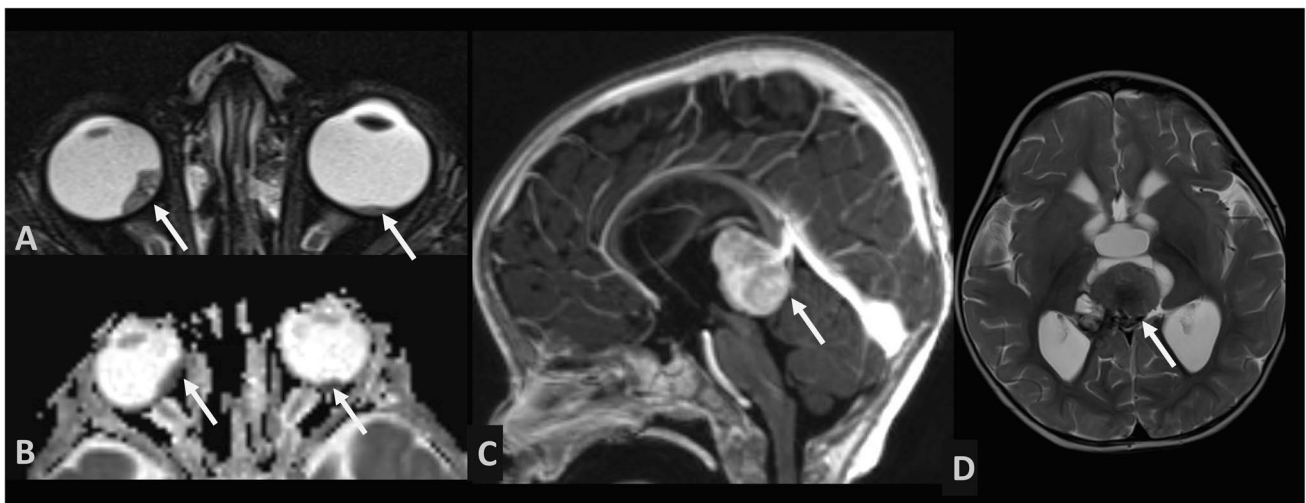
Fourteen-month-old female with trilateral retinoblastoma (RB). Axial T2WI TSE with fat-suppression A and axial DWI ADC B show bilateral lesions in the posterior aspect of the globes demonstrating low ADC values (i.e., high cellularity), consistent with RB
